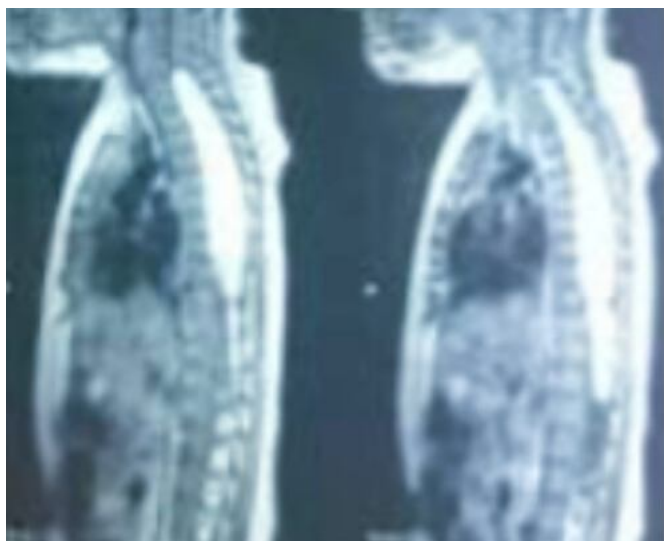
MRI whole spine, sagittal view shows a large well defined fat contained predominantly extramedullary intradural lesion extending from C5 to L1 vertebral level s/o lipoma
